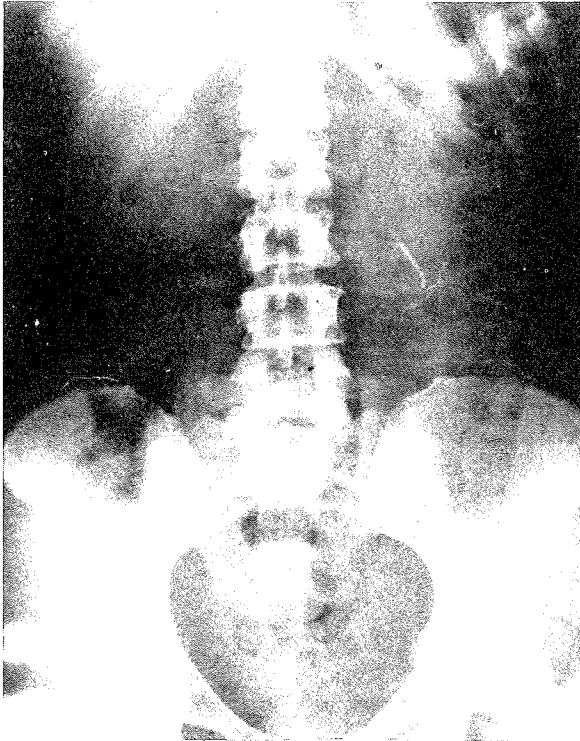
X-ray Abdomen - note the translocated Copper-7 device high up in left lumbar region.
